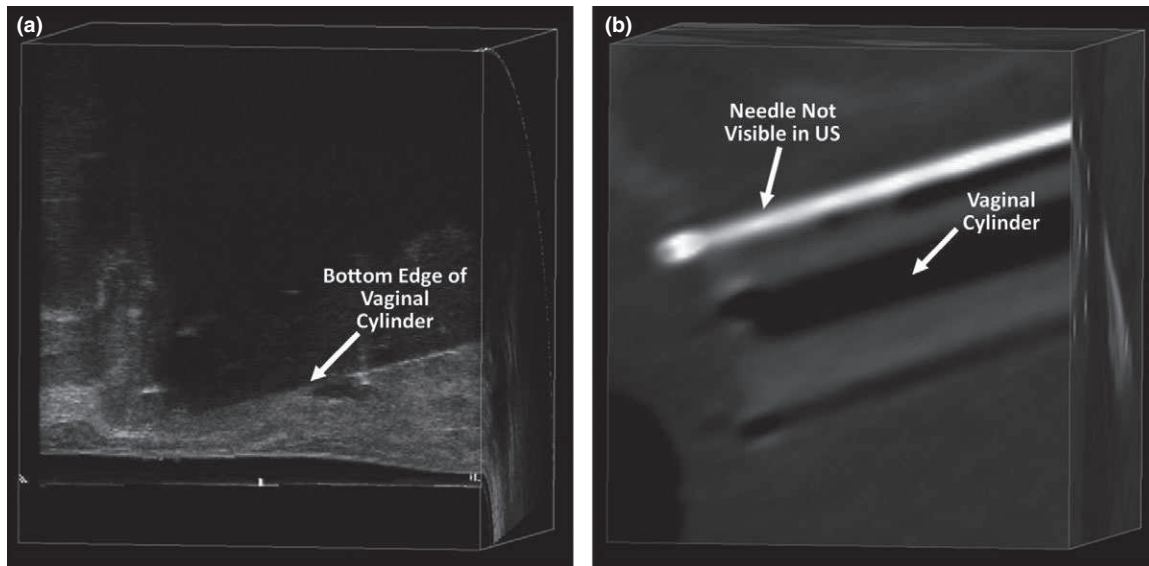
(a) 3D TRUS patient image showing shadowing created on the anterior side of the vaginal cylinder of the perineal template, with the bottom edge (posterior side) of the vaginal cylinder indicated. (b) The corresponding, registered CT scan, showing the vaginal cylinder and a needle not visible in the 3D TRUS scan due to the shadowing artifact.
